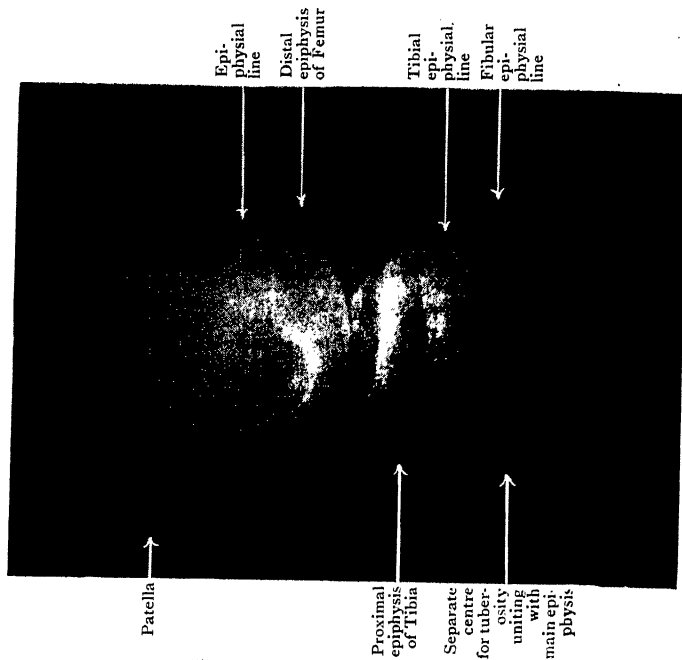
Lateral Radiograph of the same Knee in slightly flexed position.
